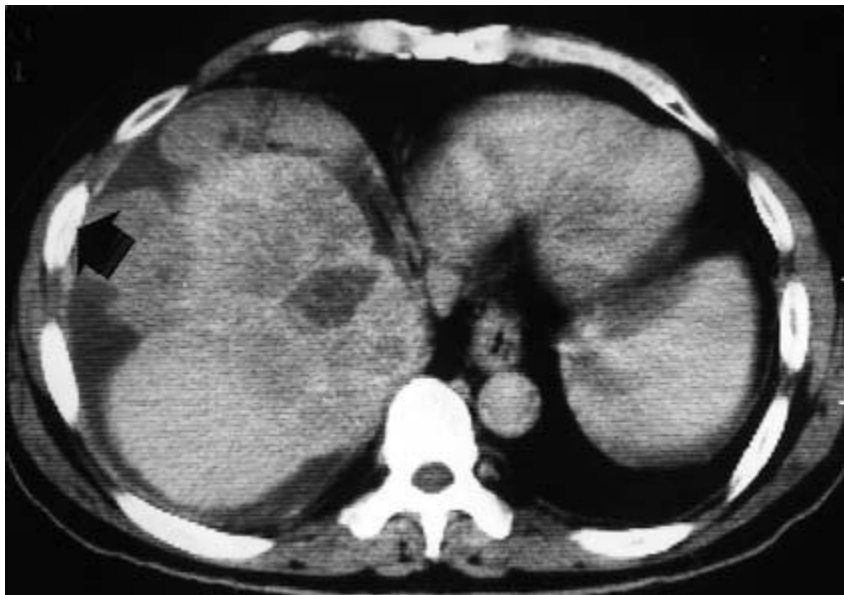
CT scan in hepato-cellular cancer shows tumour bursting through capsule (arrow). Ascites is also present.
